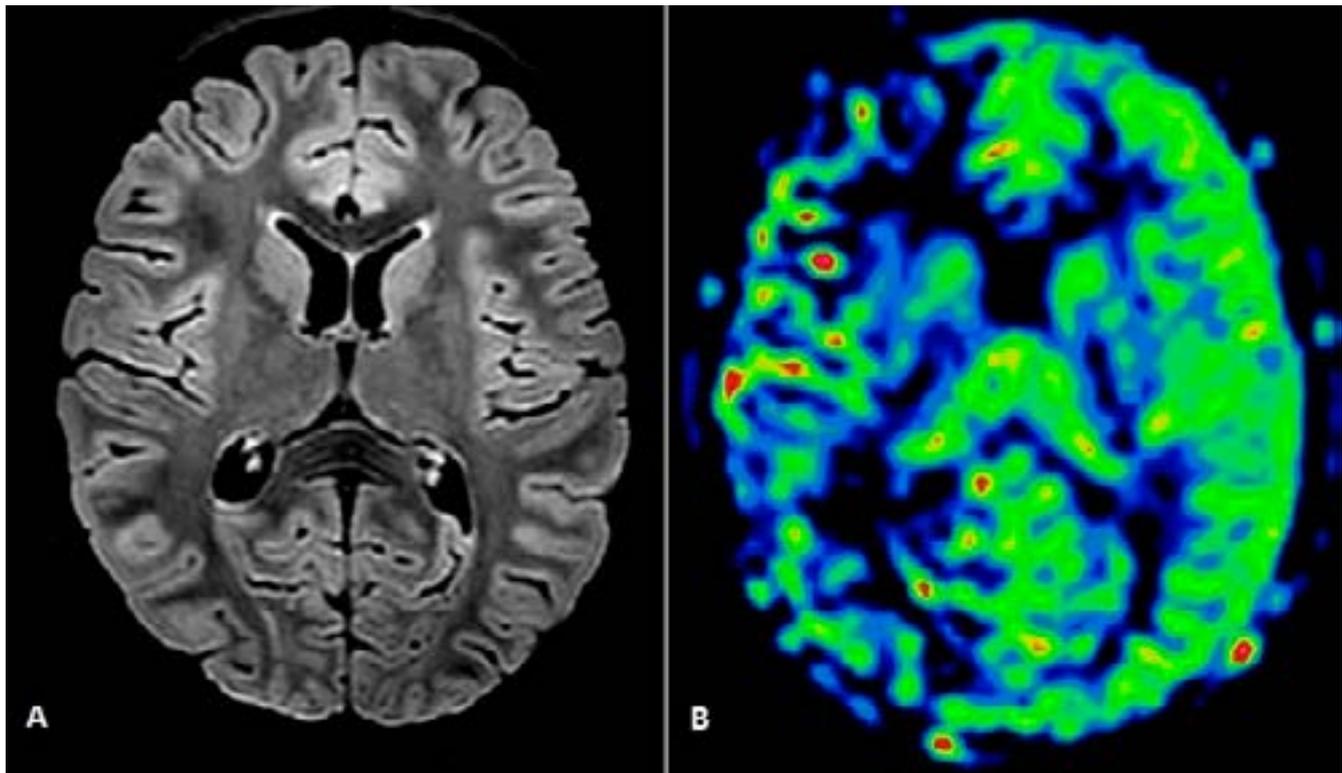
Arterial spin labelling MRI perfusion.
